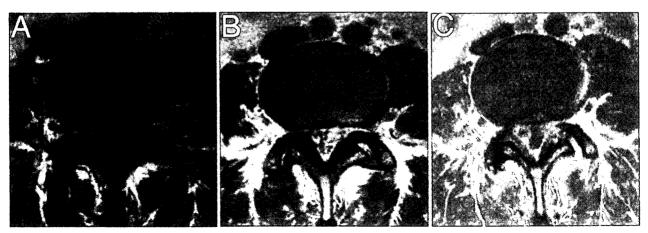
Axial T1-weighted (A), T2-weighted (B), and Gd-enhanced T1-weighted (C) MR images at L4–5 demonstrating dural sac compression by the masses. Note that the capsule in (C) enhanced with the addition of Gd-diethylene-triaminepentaacetic acid.
